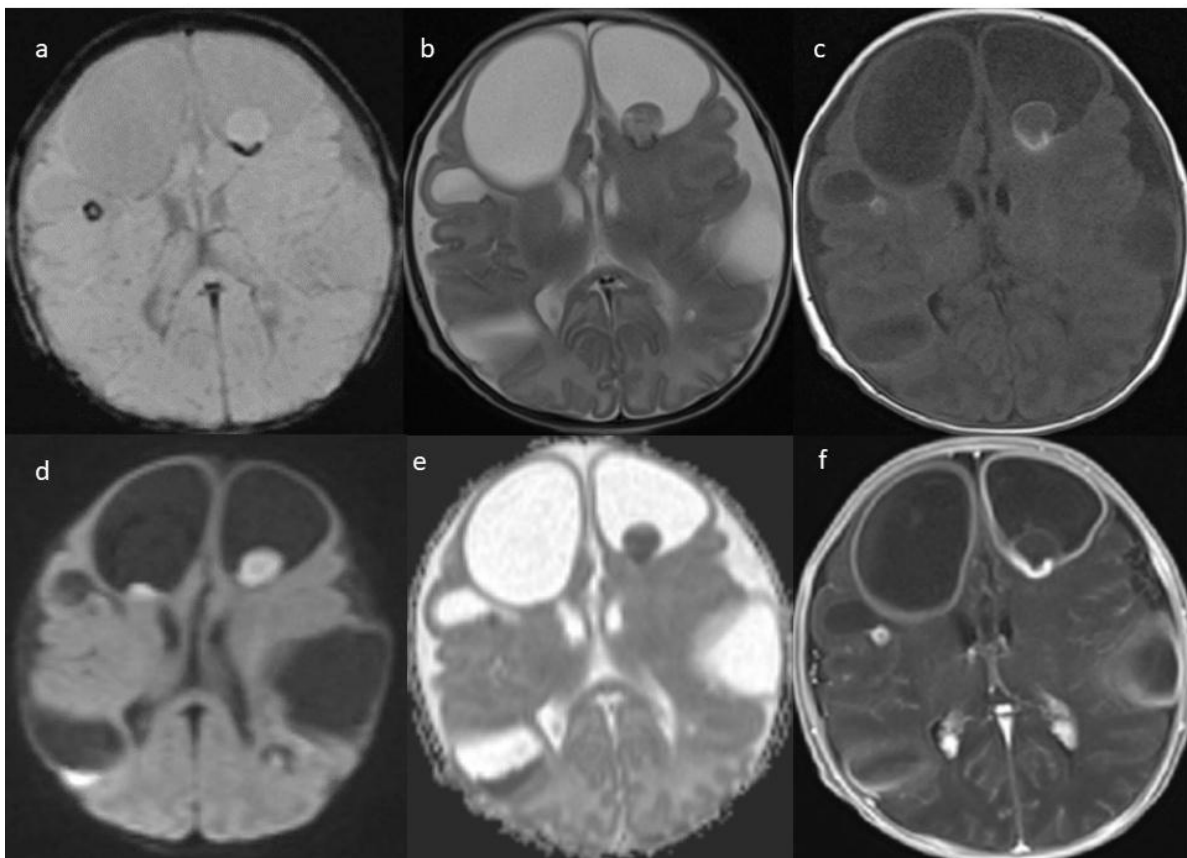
Preoperative MRI appearance of brain abscesses. a. GRE/T2*WI showing hemorrhagic elements in the abscesses. b. FSE/T2WI, c. SE/T1WI and f. SE/T1WI post-contrast demonstrated the cystic nature of the abscesses filled mainly with fluid, with enhancing walls and containing perimural nodules. d. DWI and e. ADC map showed diffusion restriction limited to the nodules.
